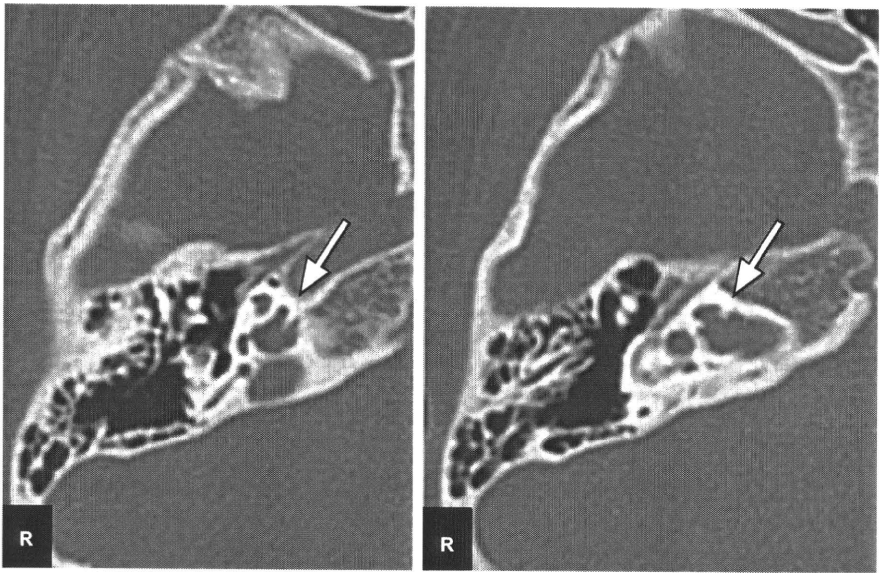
Preoperative high resolution CT scan of a patient. In this patient, two serial slices of CT images showed that the cribriform plate was absent (arrow). During the operation, perilymph/cerebello-spinal fluid gusher occurred after cochleostomy. All six patients showing perilymph/cerebello-spinal fluid gusher had inner ear anomalies.
